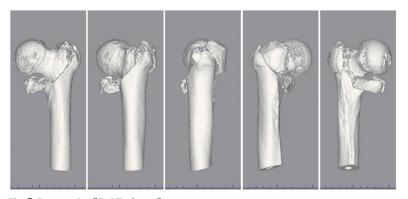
Preoperative 3D-CT of case 2.
